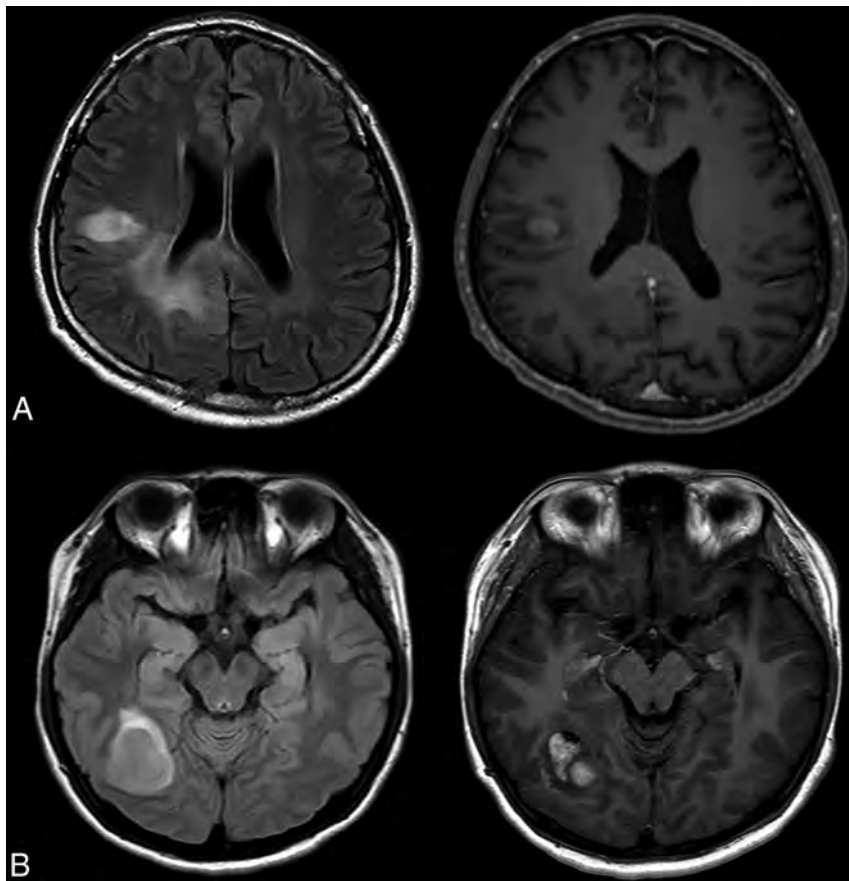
Representative cases of *IDH* wild-type lower-grade gliomas with (A) and without (B) molecular features of GBM. A, Initial MR imaging of a 49-year-old man with *IDH* wild-type lower-grade glioma with molecular features of GBM, WHO grade III. MRIs reveal infiltrative T2-hyperintense tumor in the right frontal and parietal lobes extending into the corpus callosum with cortical involvement (*left*). Focal contrast enhancement is noted in the right frontal lobe (*right*). B, Initial MRIs of a 26-year-old woman without molecular features of GBM, WHO grade III. MRIs reveal a relatively well-defined enhancing mass with peritumoral edema in the right temporo-occipital lobe without cortical involvement.
